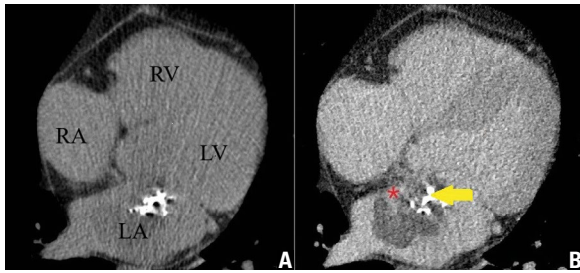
A. Axial non-contrast computed tomography image; B. Axial delayed phase contrast-enhanced computed tomography image. Images demonstrate a hypodense mass measuring 35×45 mm in the left atrium. The lesion contains calcifications (yellow arrow on image B) and contrast-enhancing vascular part (red asterisk on image B). Size of cardiac chambers is within normal limits. There are no other cardiovascular abnormalities; RA — right atrium; RV — right ventricle; LA — left atrium; LV — left ventricle.
